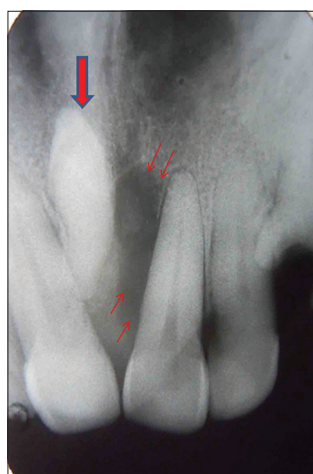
Intraoral periapical radiograph showing the inverted mesiodens and bone loss along the root of the maxillary left central incisor
